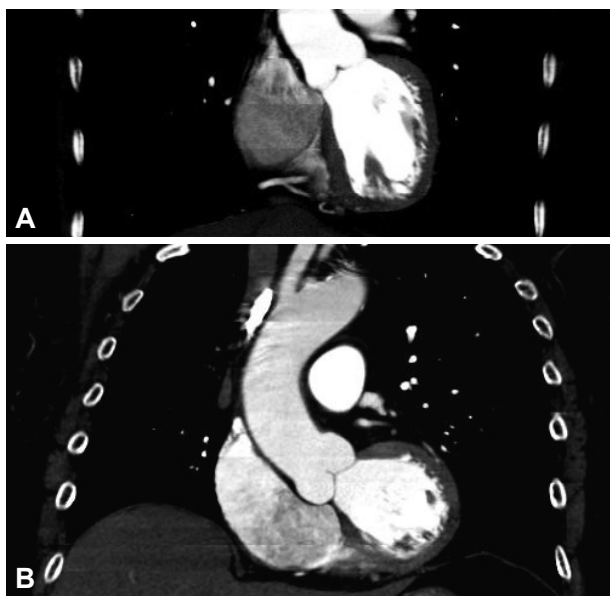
Typical Z axis coverage in dedicated coronary CT angiography versus triple rule-out study. A: the field of view in a dedicated coronary CT angiography is demonstrated. B: note the increased Z axis length in the triple rule-out study compared with dedicated coronary CT angiography.
